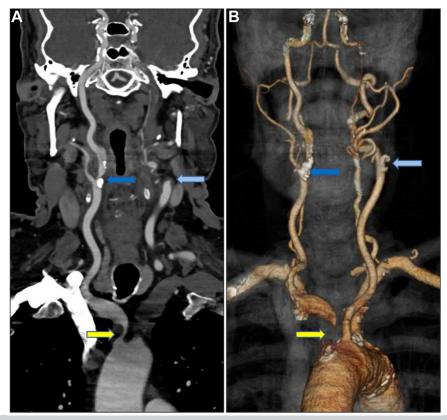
Preoperative computed tomography angiogram demonstrating noncalcified innominate artery (IA) high-grade stenosis (*yellow arrow*), right internal carotid artery (ICA) high-grade stenosis (*dark blue arrow*), and left ICA occlusion (*light blue arrow*). A, Reformatted coronal view. B, Three-dimensional reconstruction.
